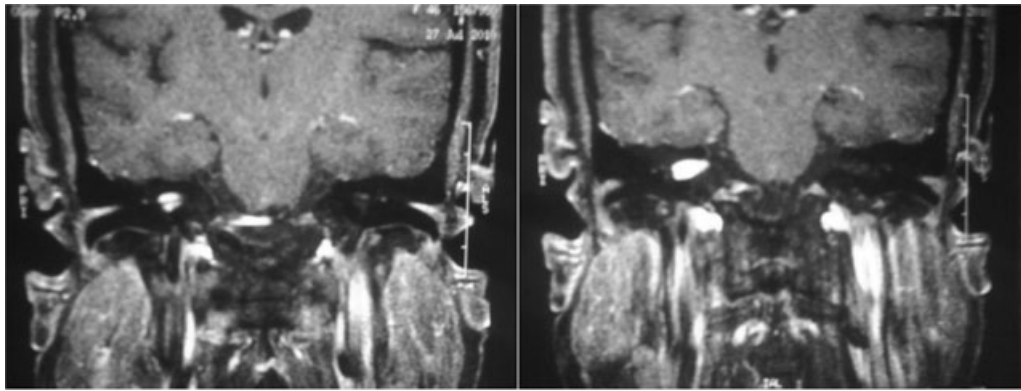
Magnetic resonance imaging showing lesion occupying the entire length of the right internal auditory canal (5 × 6 × 14 mm) with lateral margin establishing contact with the bottom of the canal and labyrinth without extension.
